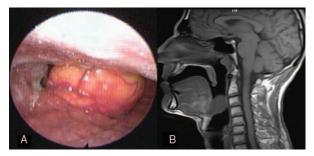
A, Flexible laryngoscopic view of huge vallecular cyst. B, Sagittal T1 magnetic resonance image showing a vallecular cystic mass subtotal narrowing the airway.
